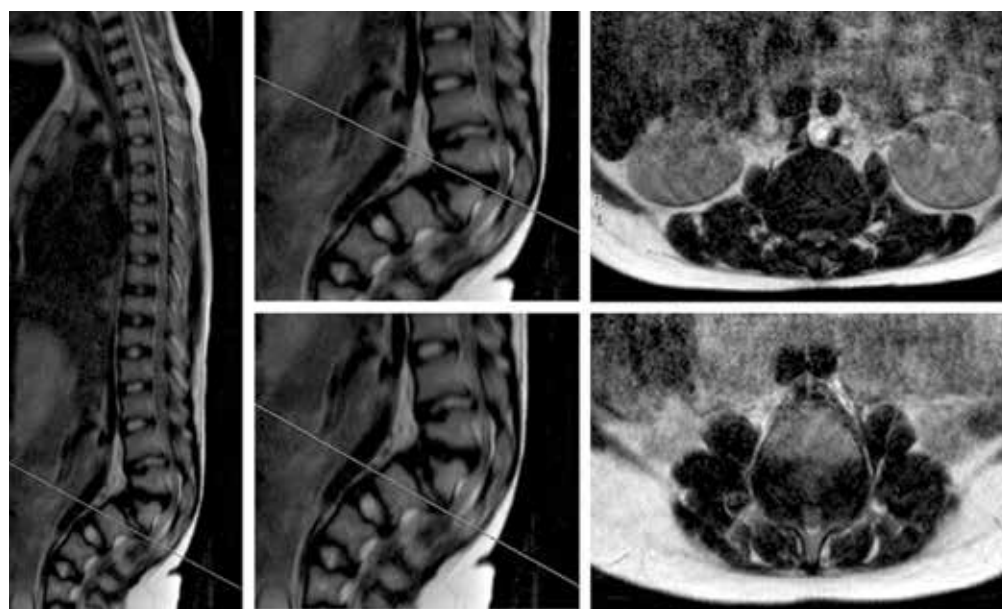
Case 1: sagittal and axial MRI sections demonstrating spinal canal stenosis and thoracolumbar gibbus.
